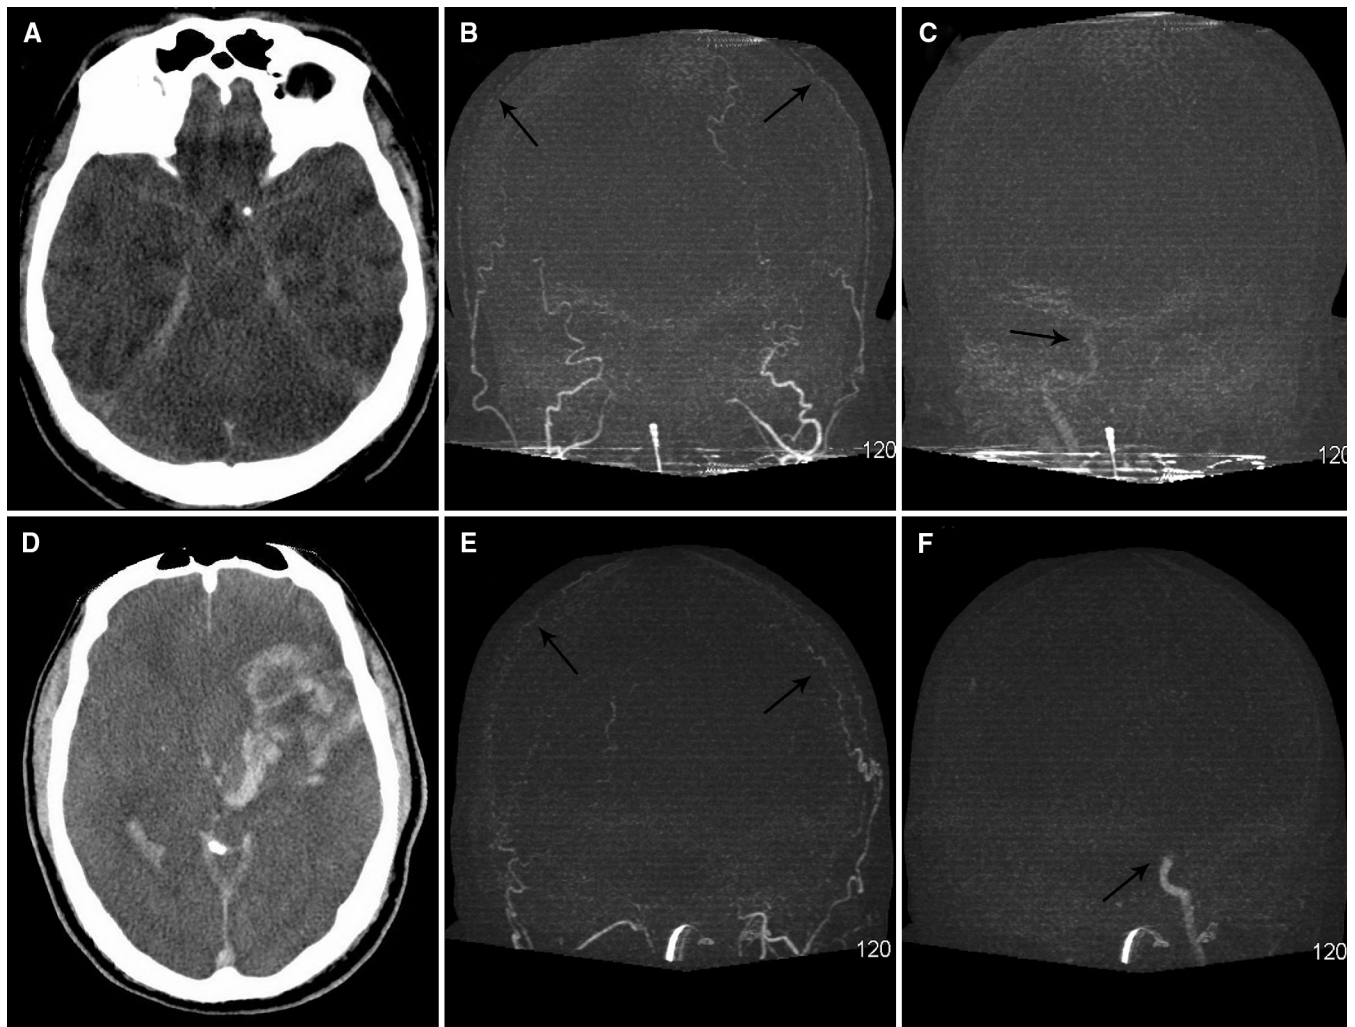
(A-C) Case 2. (A) Noncontrast computed tomography (CT), showing evidence of pseudosubarachnoid hemorrhage with “reversal sign” of grey matter hypodensity. (B) Dynamic CT angiography at 22 seconds, showing good flow in the external carotid branches to the level of vertex (black arrows) but no evidence of flow in internal carotid arteries (ICA) and intracranial branches. (C) At 60 seconds, there was meager contrast flow noted in the right ICA only to the level of the skull base (black arrow); please note the scalp arteries have completely cleared of contrast. (D-F) Case 3. (D) Noncontrast CT of the head, showing evidence of subacute infarction, with hemorrhagic transformation, intraventricular hemorrhage, and mass effect; subtle loss of grey-white matter differentiation was noted. (E) Dynamic CT angiography at 28 seconds, showing filling of the scalp arteries (black arrows) without any intracranial branches. (F) Delayed image at 70 seconds, showing contrast filling in the left ICA to the level of the cavernous segment (black arrow); intracranial blood flow is absent.
